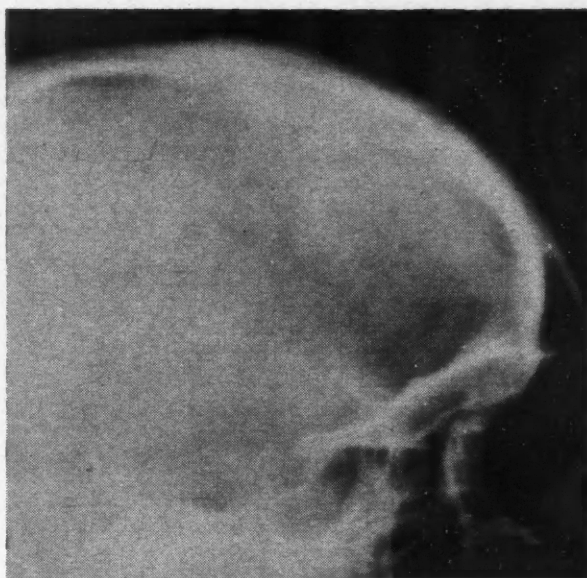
(b).—Radiograph, November 16, 1954 (had radiation castration in 1953 followed by adrenalectomy March 3, 1954). Note almost complete healing and recalcification of metastatic lesion continuing at 8 months postoperatively.
